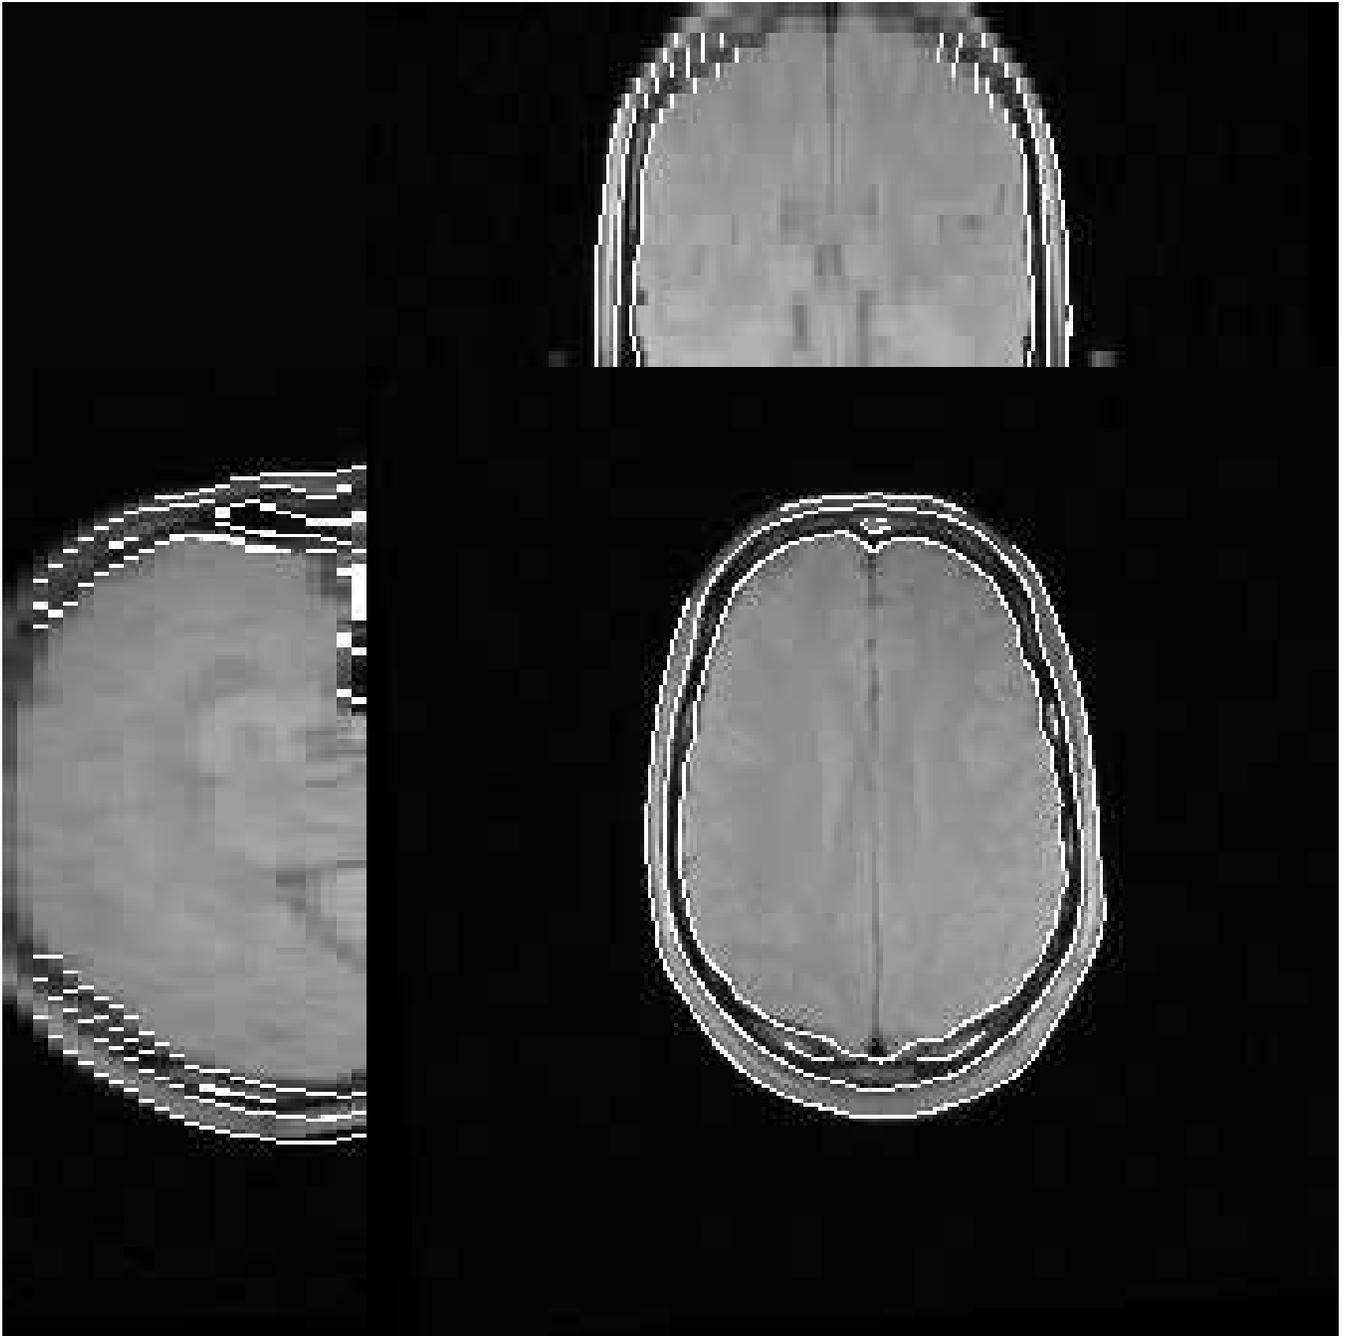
A final configuration for MR-CT registration by maximization of mutual information. The three central slices of the MRI data are shown with the edges from the registered CT data overlaid.
